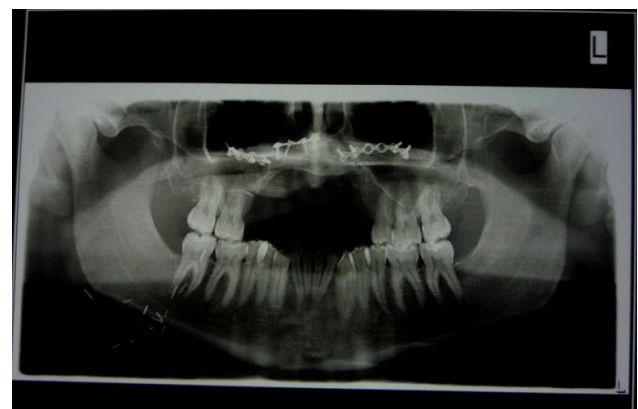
Panoramic radiograph after surgery
